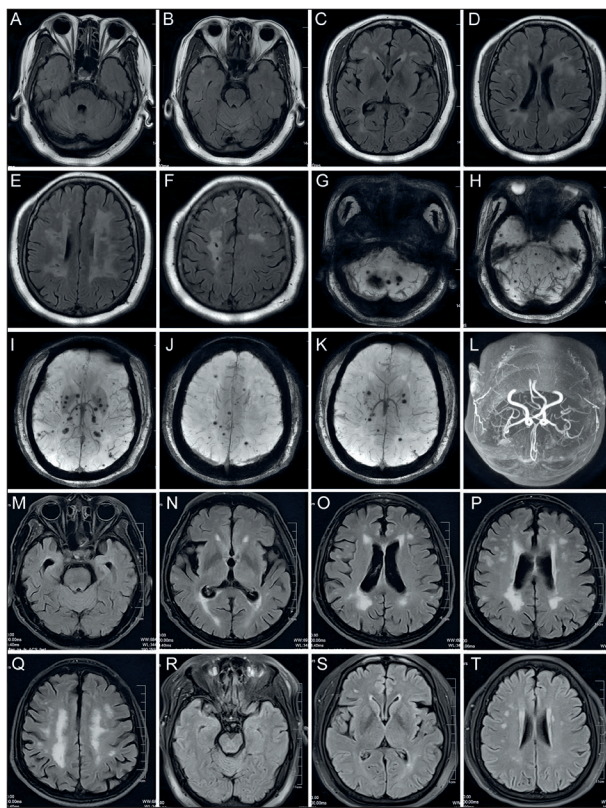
Brain MRI findings of the proband and affected family members. A-L, Brain MRI features of the proband. A-F, T2-weighted and fluid-attenuated inversion recovery (FLAIR) sequences show diffuse white matter hyperintensities (WMHs) predominantly in the bilateral periventricular white matter, centrum semiovale, and basal ganglia. G-K, Susceptibility-weighted imaging (SWI) reveals multiple cerebral microbleeds (CMBs) in the cerebral hemispheres, bilateral thalami, cerebellar hemispheres, and brainstem. L, Magnetic resonance angiography (MRA) demonstrates no vascular stenosis or occlusion in the examined vessels. M-Q, Brain MRI of the proband's eldest brother (Figure 1A, II:1) shows multiple confluent patchy hyperintensities involving the bilateral frontal, temporal, and parietal lobes, bilateral corona radiata, and centrum semiovale, with concomitant passive triventricular hydrocephalus (N) and bilateral hippocampal atrophy and degeneration (M). R-T, Brain MRI of the proband's younger sister (Figure 1A, II:7) shows multiple patchy hyperintensities on T2-FLAIR sequences involving the bilateral centrum semiovale and corona radiata.
